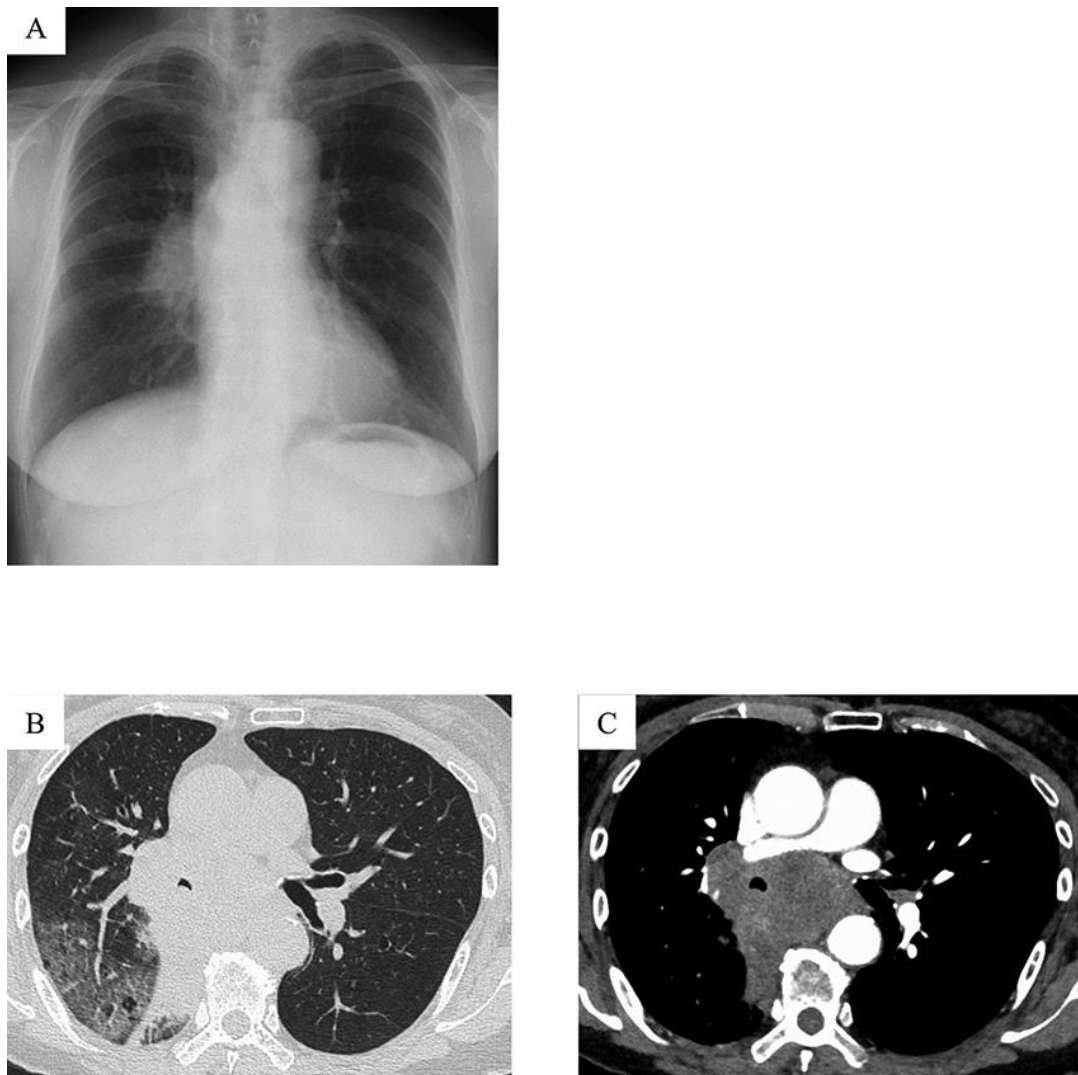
Findings on chest radiography and CT. (A) Chest radiography shows a mass on the right hilar region. (B, C) Chest CT shows an 80-mm lobulated mass on the right hilar region and multiple lymphadenopathies in the right hilum, mediastinum, and right supraclavicular fossa. CT, computed tomography.
